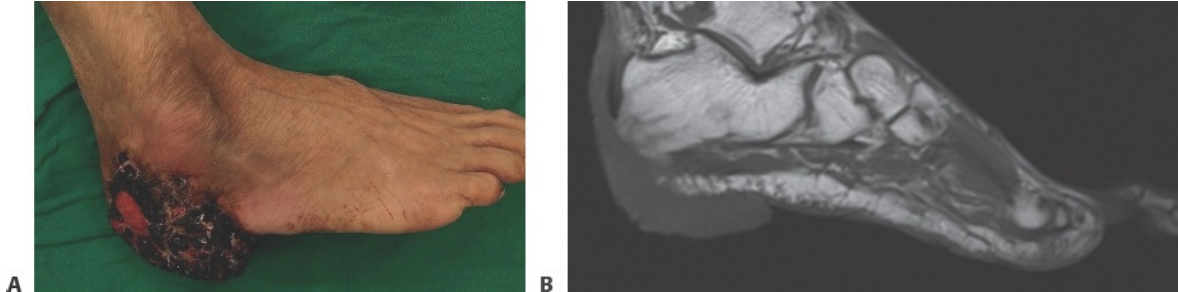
• A. Cauliflowerlike tumor on the right heel. B. MRI shows the tumor has a close relationship with the calcaneus bone and the Achilles tendon. A flap would be needed to cover this defect after tumor resection because there will be an exposure of both the bone and tendon.
